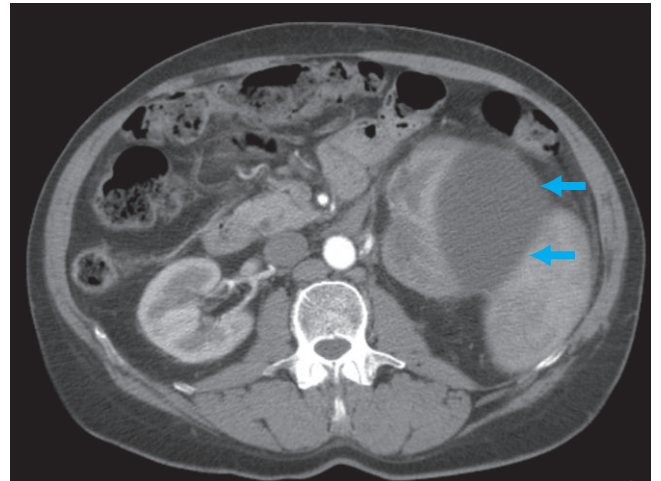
CT images from the same patient redemonstrate the subcapsular collection (arrows) and associated mass effect distorting the underlying native kidney.
